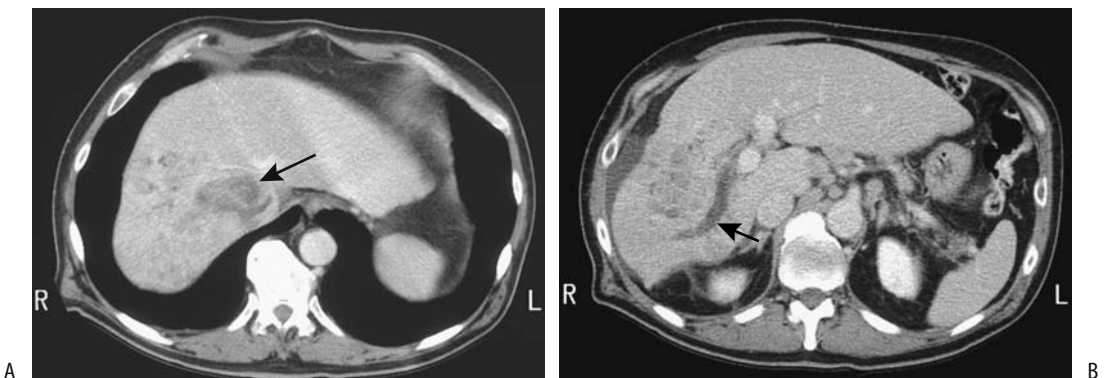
Hepatocellular carcinoma. A: More cranial CT shows an inferior vena cava thrombus (arrow). B: More caudal image reveals the tumor and a right portal vein thrombus (arrow). Adenopathy is also present. (Courtesy of Patrick Fulz, M.D., University of Rochester).
